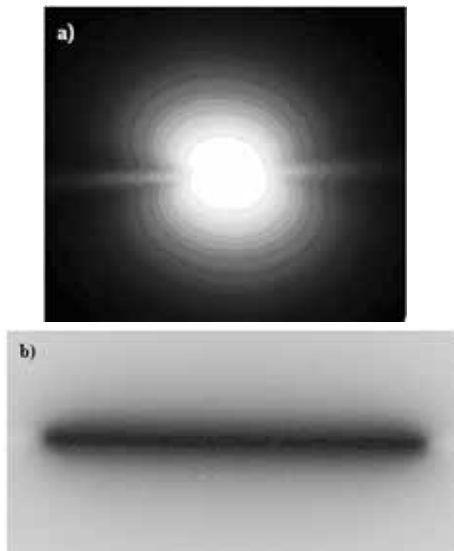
Auto radiographs of a conventional seed type source (A) and a 5.0cm long RadioCoil^{TM103}Pd linear source (B).
